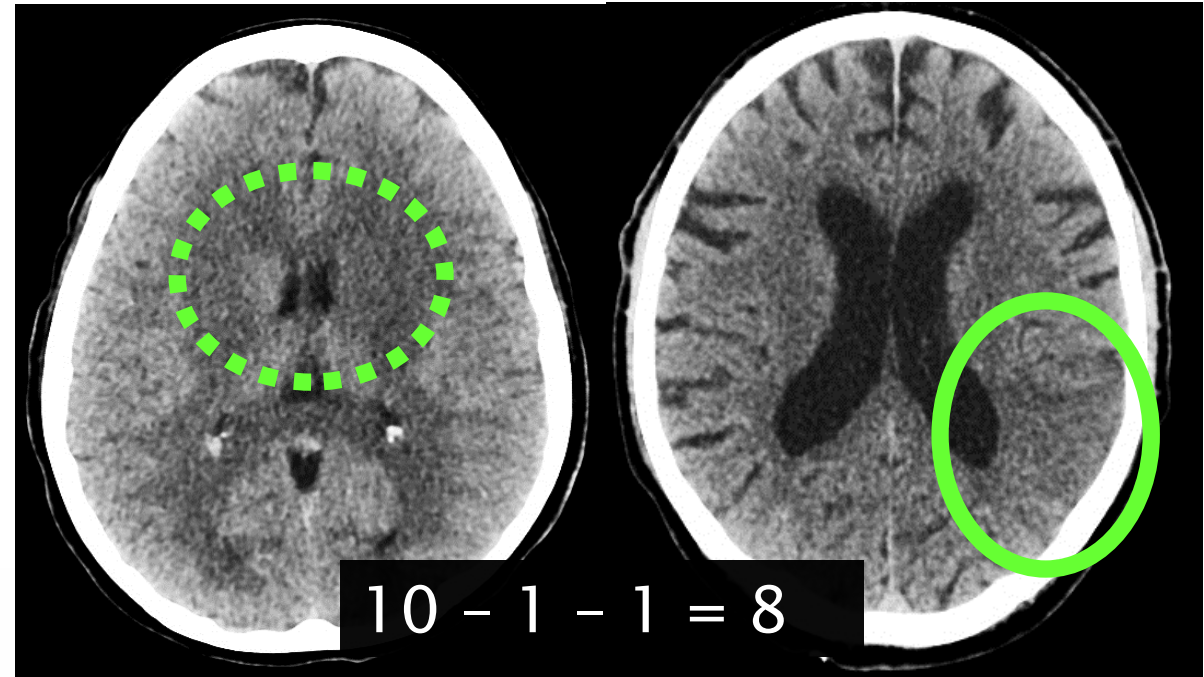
ASPECTS study form
